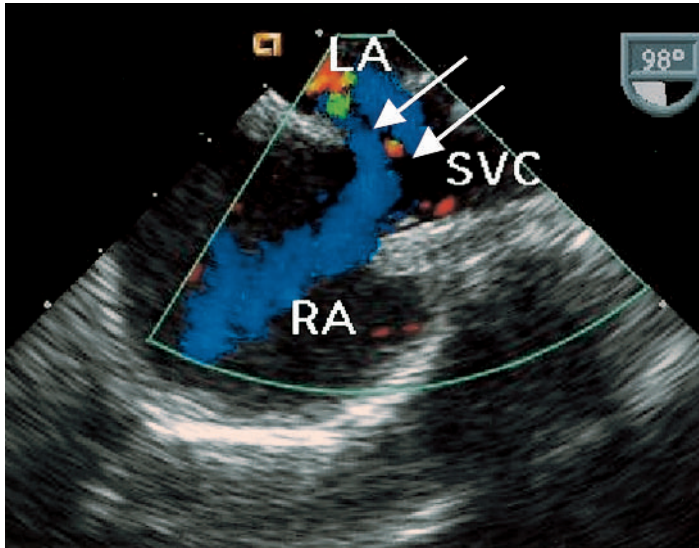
(b) Sinus venosus atrial septal defect. Color Doppler exam of a superior vena cava-type sinus venosus atrial septal defect in the bicaval view. Left-to-right shunting across the defect is noted in the superior aspect of the interatrial septum (arrows).
